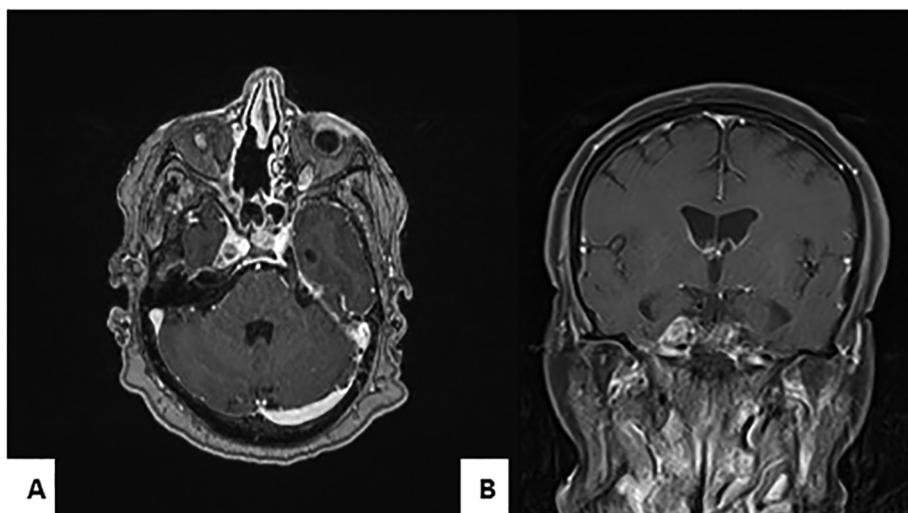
Axial (A) and coronal (B) T1-weighted postoperative MRI demonstrating continued enhancement within Meckel's cave and expected postoperative changes.
